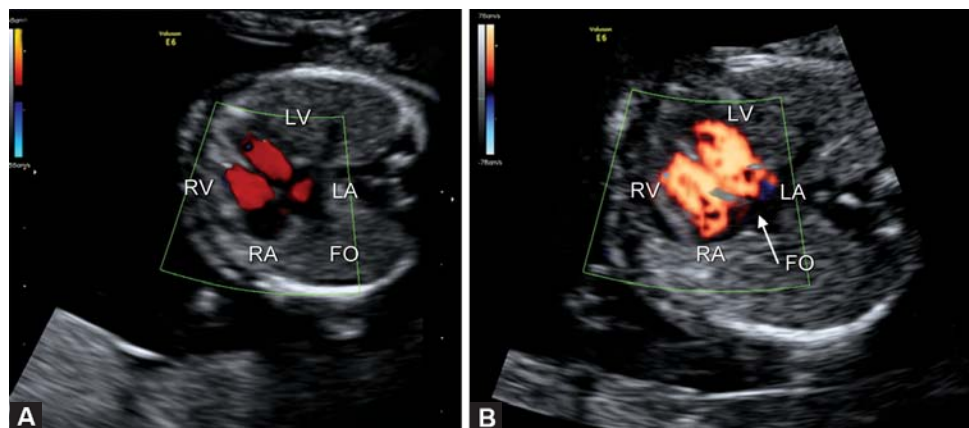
Early fetal echocardiography by 2D and Color Doppler in a structurally normal heart. (A) 4-chamber view—2D. (B) 4-chamber view—2D and color Doppler. RV: right ventricle; LV: left ventricle; RA: right atrium; LA: left atrium; FO: foramen ovale; DAo: descending aorta
